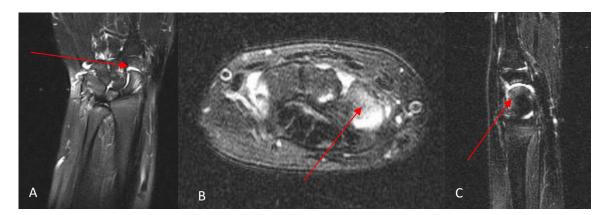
MRI sections demonstrating effusion in the intercarpal joint (A) and bone edema (B, C) in the distal scaphoid of the left wrist shown with arrows.
